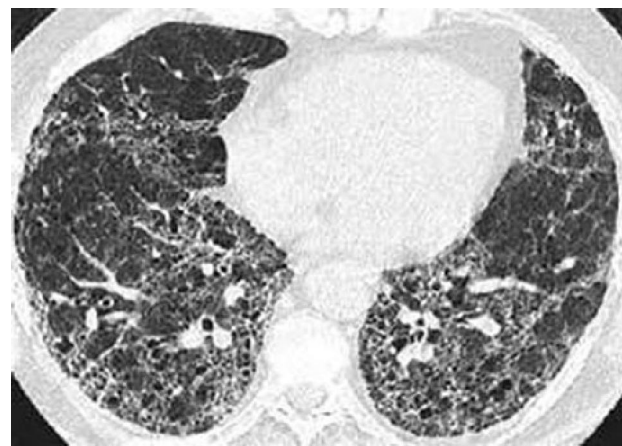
HRCT of an IPF patient
